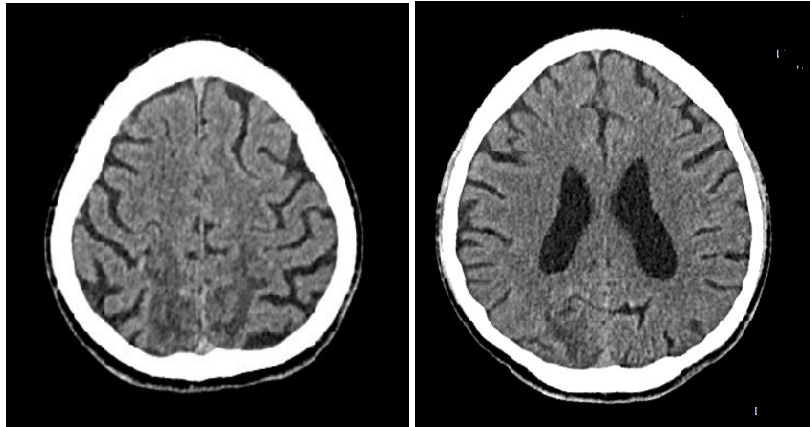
CT images of PRES (vasogenic edema in parieto-occipital region) in covid-19 patient.
